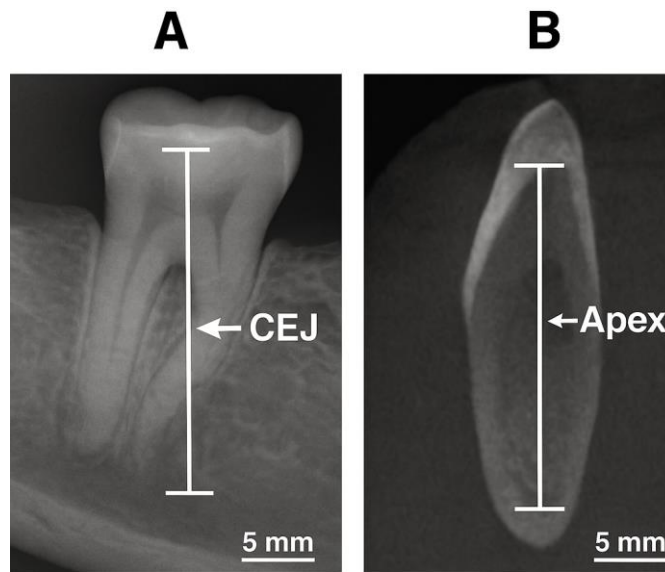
Radiographic Measurement Protocol (CEJ–Apex Root Length)
